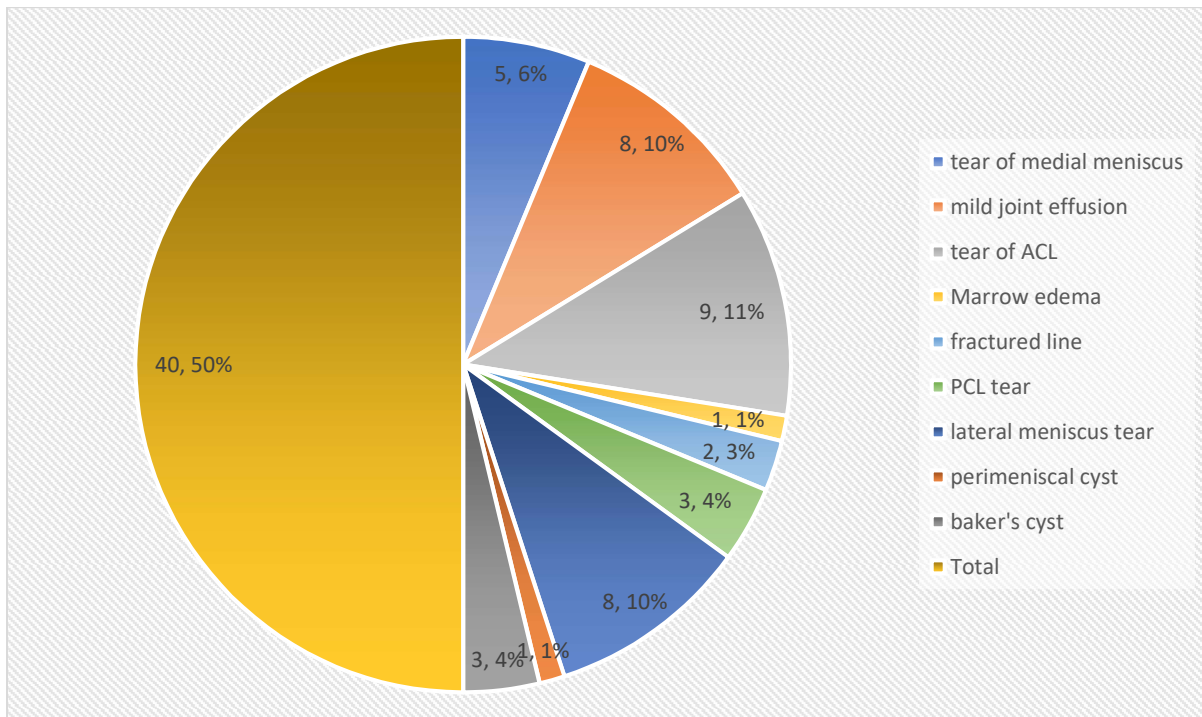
Distribution of MRI findings as per number of findings in patients
